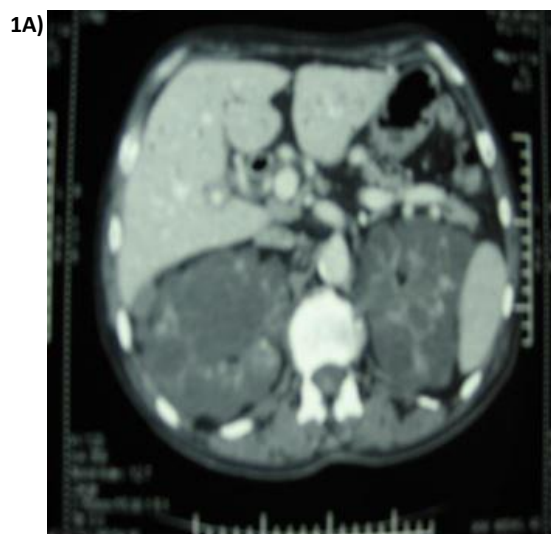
CT with contrast medium. Apparent multiple cysts with marked dilatation of the intrahepatic and extrahepatic bile ducts, especially of the common bile duct. Complete disruption of polycystic kidneys which have considerable size.
